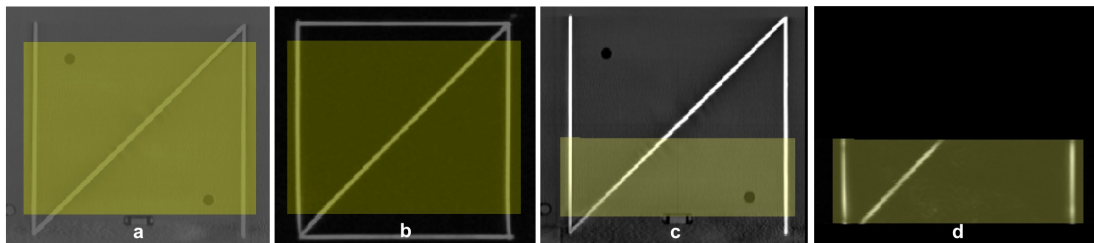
The fiducials and the volume of interest (VOI, the yellow zone) in which the registration error is calculated. In (a) and (c) are shown the CT fiducials, in (b) those from the T1w images and in (d) from the T2 CISS. The ROI for the T1w images is represented in (a) and (b), while (c) and (d) show the ROI for T2 CISS.
